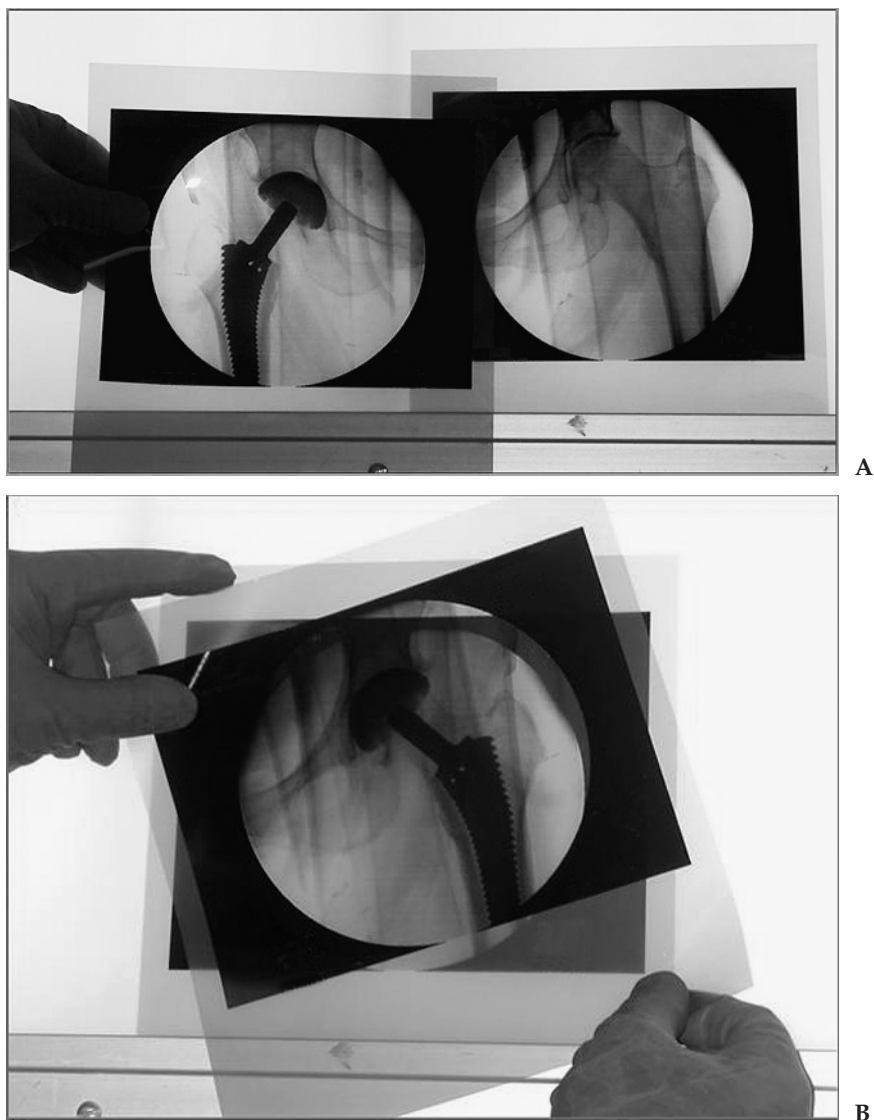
(A) X-ray prints of the right hip with trial femoral components and a normal left hip. (B) Assessment of leg length and femoral offset: Right hip transparency with trial components is flipped and placed over the left hip transparency.
